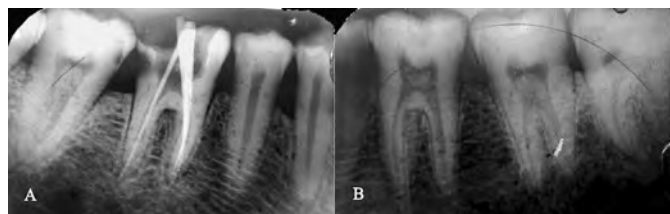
(Left) Periapical radiograph showing the presence of C-shaped root on the mandibular left second molar. (Right) Radiograph of the mandibular right second molar showing two separate roots. Case is 22 year old female.
